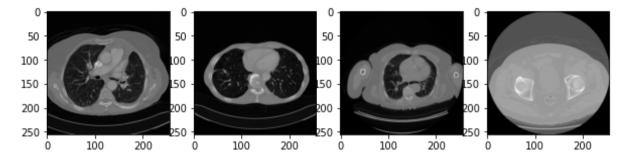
Sample CT images from the TCGA/TCIA dataset.
